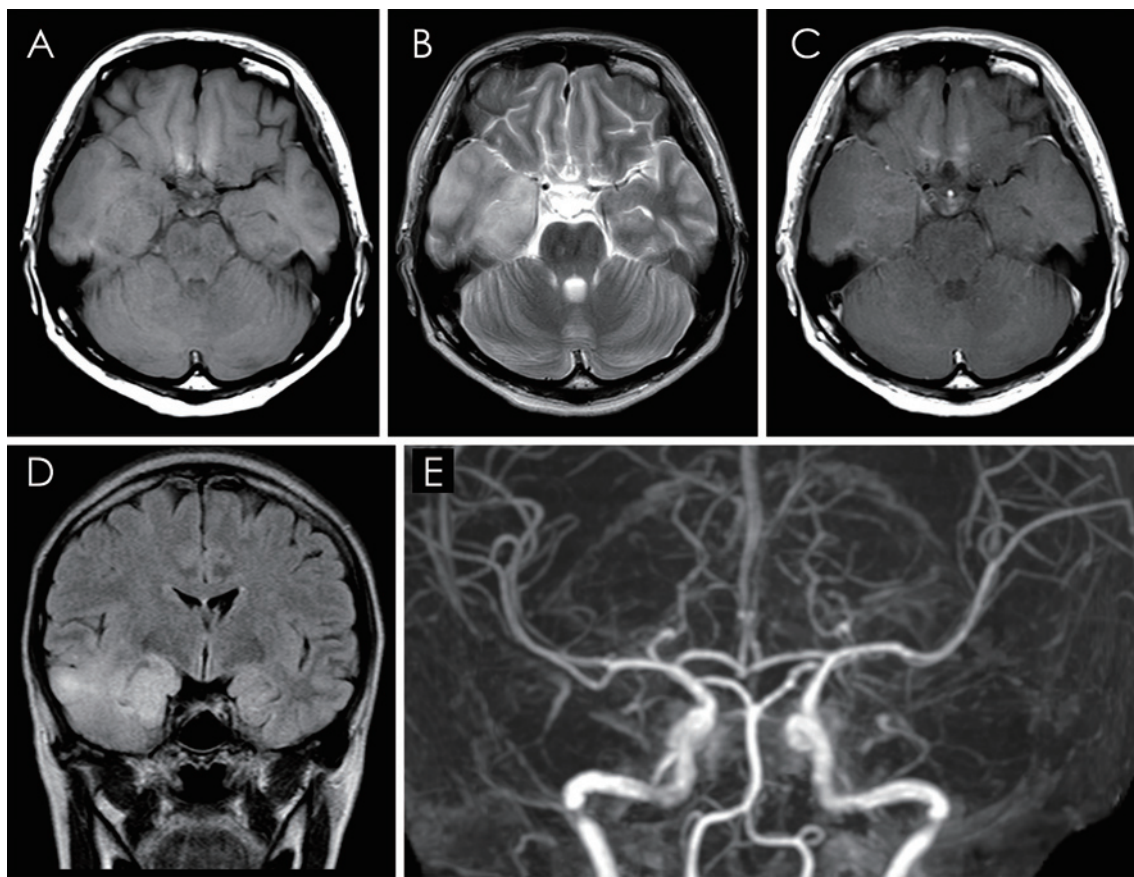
Preoperative MRI image shows a tumorous lesion on the right medial temporal lobe. (A, T1-weighted imaging; B, T2-weighted imaging; C, T1-weighted imaging with contrast; D, Coronal FLAIR imaging.) MRA reveals no stenosis or atherosclerosis of the cerebral arteries (E).
